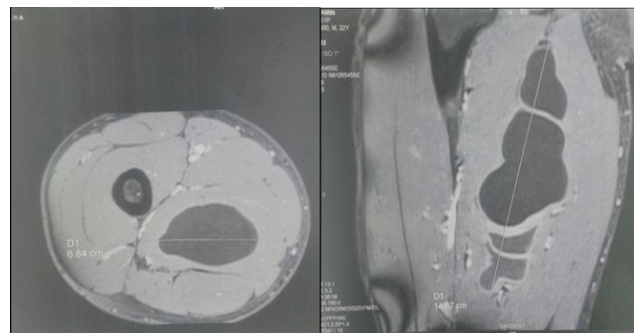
Contrast-enhanced magnetic resonance images of a cystic mass arising from the origin of the right adductor magnus.
